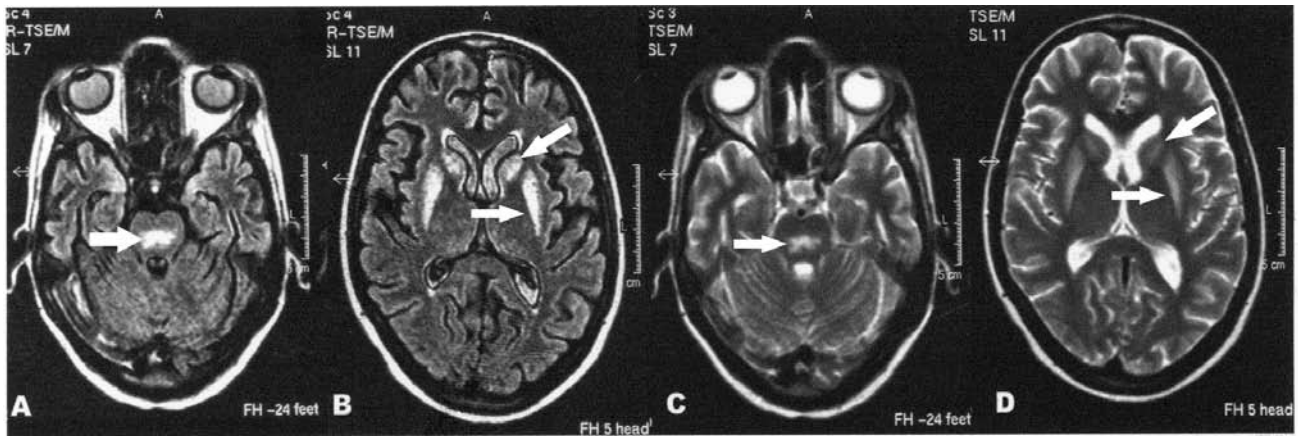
Axial FLAIR (fluid attenuated inversion recovery) sequence (a & b), axial T2 weighted images (c & d) showing increased signal intensity in central portion of upper pons (a & c), bilateral lentiform nuclei and head of caudate nuclei (b & d) (arrows). Notice the symmetric involvement of the basal ganglia.
